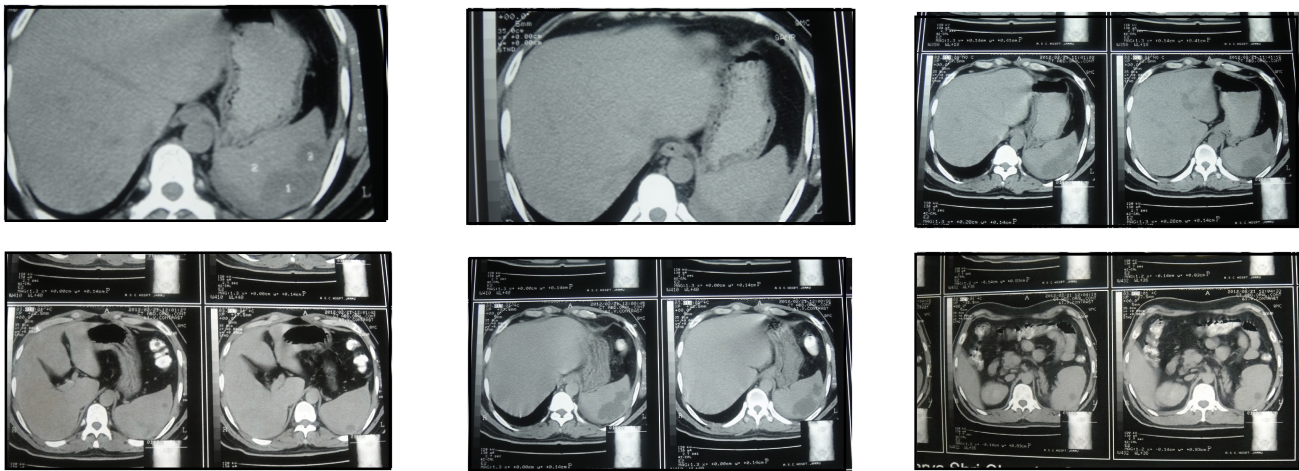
CT Showing Multiple Splenic Abscess with Hepatosplenomegaly & left sided Pleural Effusion & Basal Atelectasis
